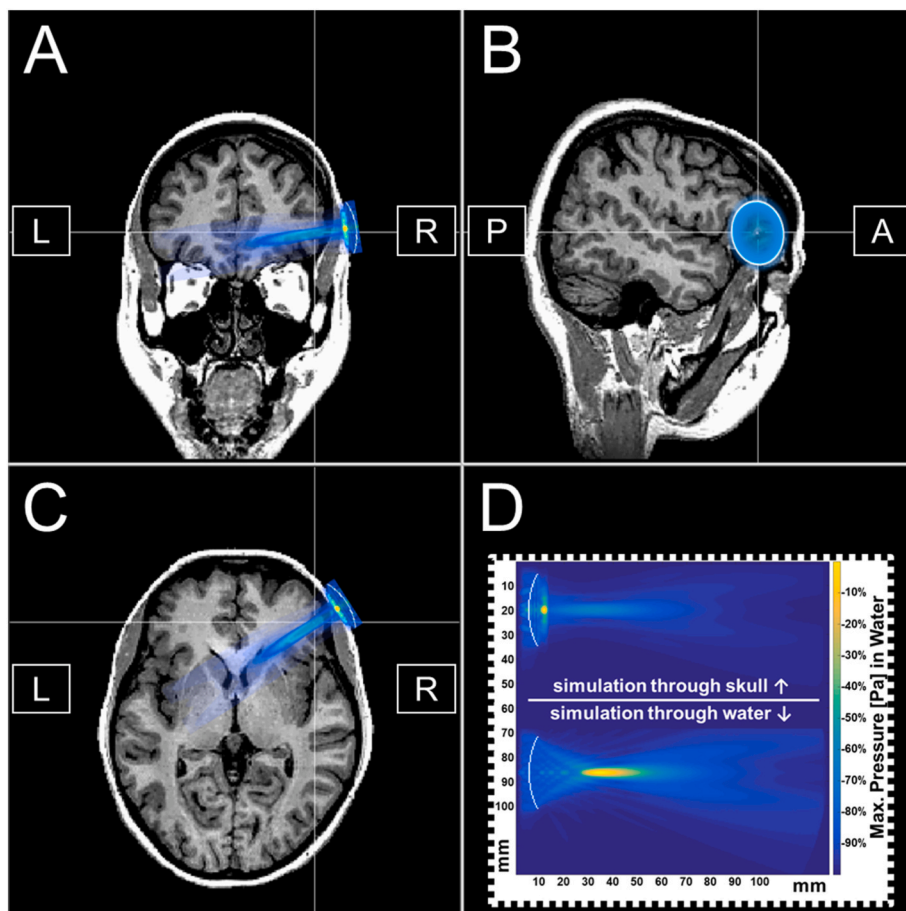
Acoustic beam modelling of our transcranial ultrasound neuromodulation (TUS) targeting the right prefrontal cortex via electroencephalography position F8. Figure originally published in <https://psyarxiv.com/g97ky/> (CC-BY Attribution 4.0 International). This figure has been created using SMART FUS [85] and a representative template brain scan provided by BrainVoyager (<https://www.brainvoyager.com/>). For SMART FUS, the following parameters were applied: bone thickness in mm = 3.1, focal depth of the TUS transducer in mm = 30, application angle in degrees = 90, fundamental TUS frequency in kHz = 500, and diameter of the TUS transducer in mm = 30.
